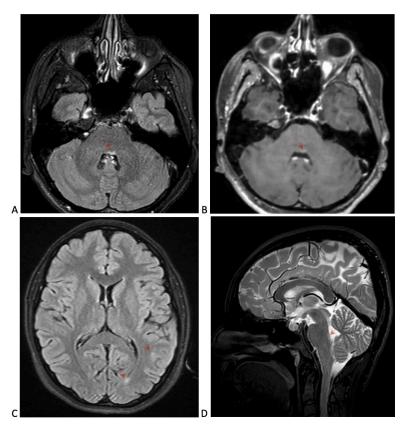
Red arrows; hyperintense demyelinating lesion in the facial colliculus (A and D), mild contrast enhancement (B), periventricular and juxtacortical demyelinating plaques (C). A,B and D; CISS, C; FLAIR MRI
